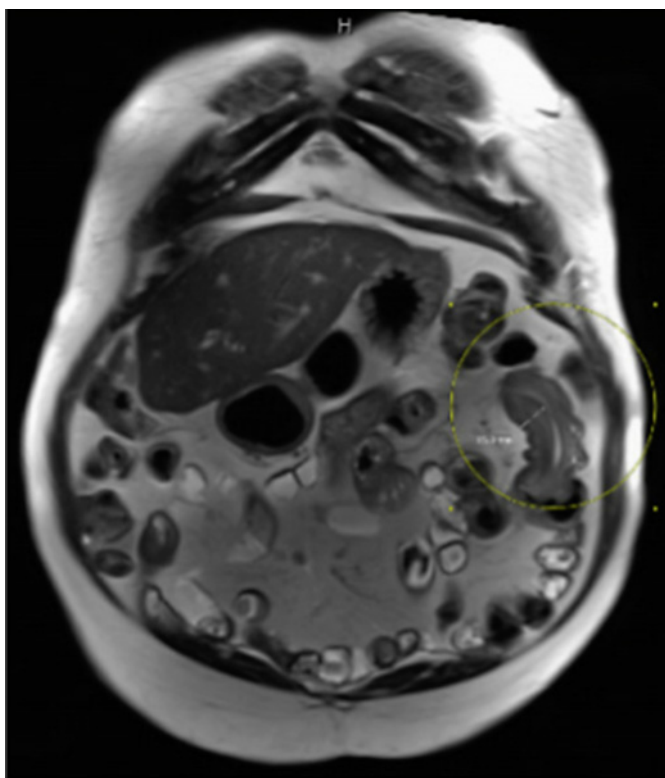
MRI demonstrating enteroenteric intussusception measuring approximately 7.7 cm in length with a 4.7 cm jejunal lesion just distal to the site of intussusception. The lesion appears to lose signal, indicating the presence of fat.
